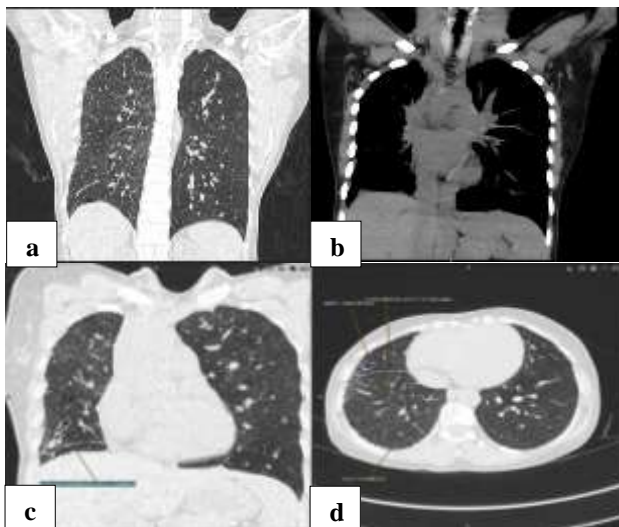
(a) and (c) High resolution computed tomography with coronal reformatted images, (b) soft tissue reconstructed image shows mild reduction in right lung volume with hyperinflation of left lung and subpleural honey combing and interstitial septal thickening, and (d) few varicoid bronchiectatic changes seen in right lower lobe.
